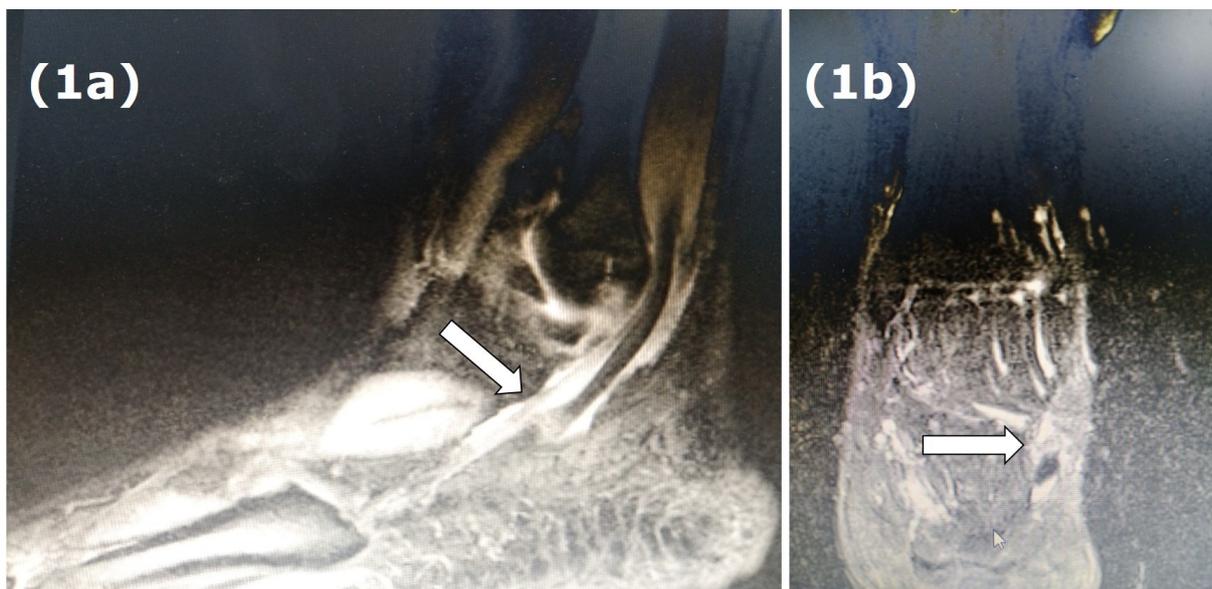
T2 weighted MRI left ankle sagittal view (a) and coronal view (b). Arrows show an oedematous peroneus brevis tendon
